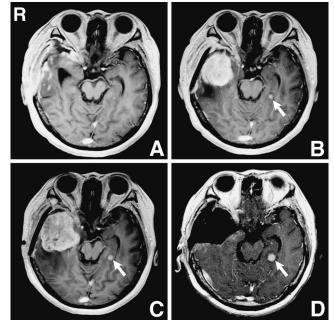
A: T_1 -weighted magnetic resonance (MR) image with gadolinium showing subtotal removal of tumor. B: T_1 -weighted MR image with gadolinium obtained 43 days after the operation showing dissemination in the left temporal lobe (arrow) and tumor recurrence (size, $41 \times 39 \times 37$ mm). C: T_1 -weighted MR image with gadolinium obtained 55 days after the operation (tumor size, $54 \times 53 \times 57$ mm) showing the diameter of the disseminated lesion is 7.0 mm (arrow). D: T_1 -weighted MR image with gadolinium obtained 64 days after the operation showing complete resection of the tumor and growth of the disseminated lesion (diameter, 9.7 mm; arrow).
